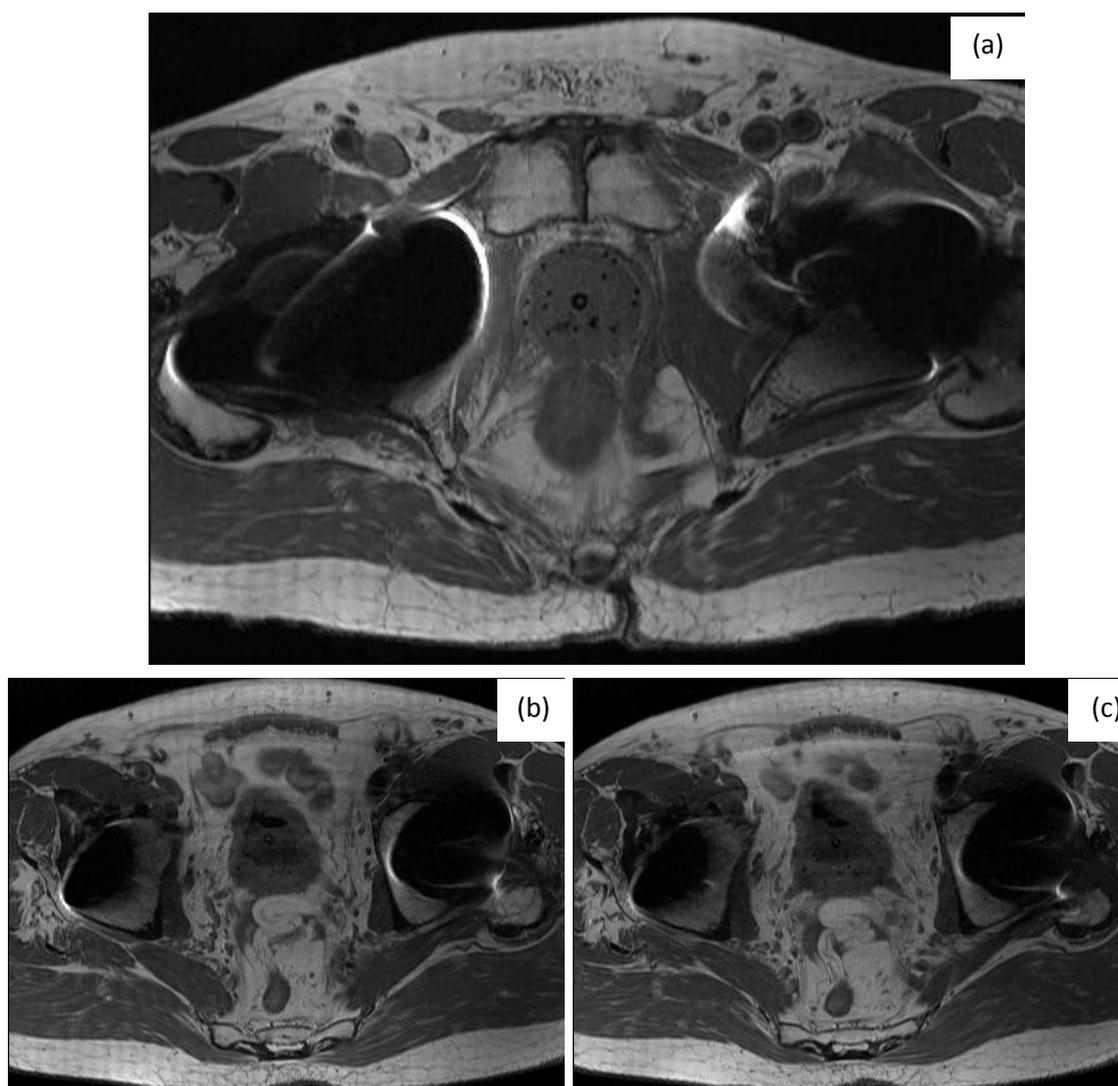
MR images from patient #1 (a) near centre of prostate, (b) and (c) towards distal ends of implanted plastic needles. The prostate is near the centre of each image. Implanted needles are visible as small black dots in the prostate. T1 TSE, 904 ms TR, 11 ms TE, COL phase encoding direction, 150° flip angle, 3 mm slice thickness, bandwidth 150 kHz.
